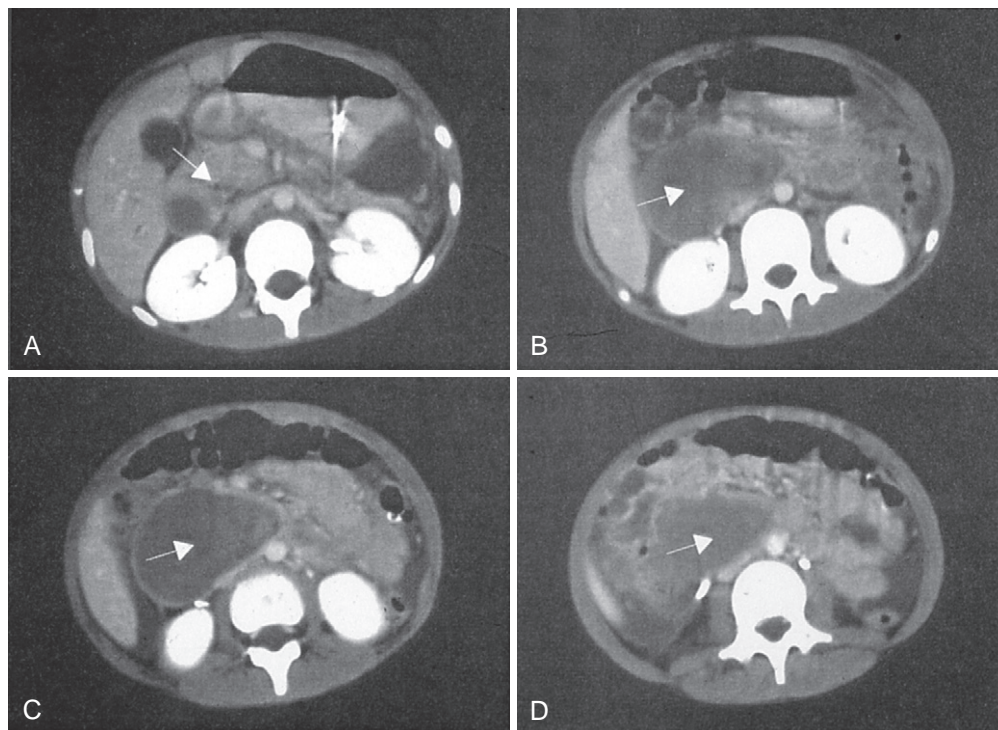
Abdominal computed tomography findings in an 8-year-old girl who sustained a duodenal hematoma after a fall at a playground. A, The arrow points to the markedly narrowed duodenal lumen. B to D, The arrows point to the large intramural hematoma. The child was treated with nasogastric suction and total parenteral nutrition. She was eating a regular diet 24 days after her injury.
